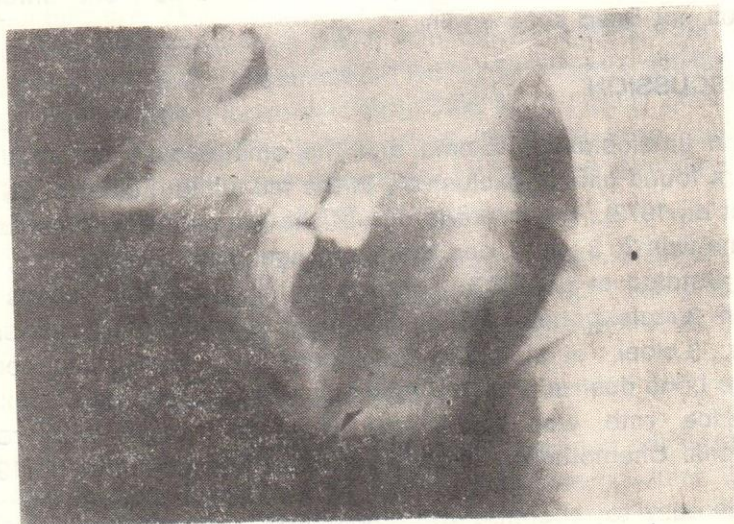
Radiograph of the left side of the mandible demonstrates radiolucent area behind the first molar. Note the track leading to the lower border (arrow).
